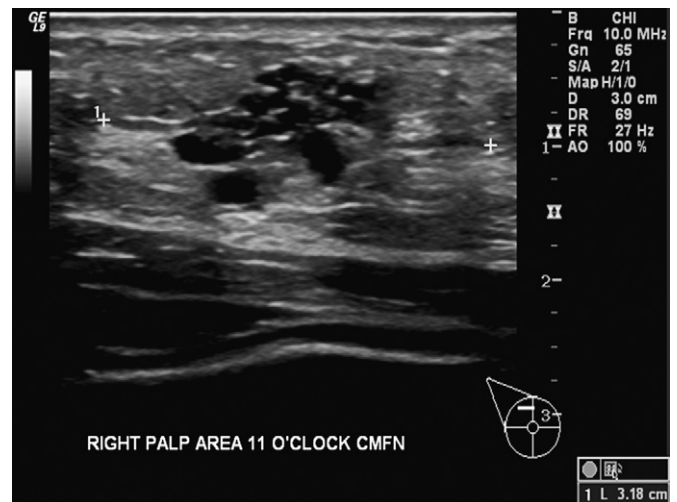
Transverse sonographic image, showing dilated irregular ducts within the retroareolar region. A 46-year-old woman presented with palpable lump. Pathology results proved high-grade ductal carcinoma in situ.
